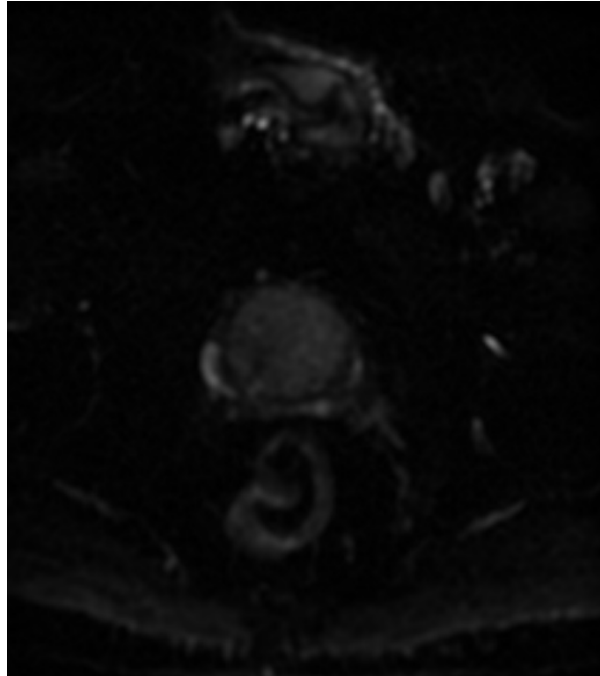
Axial DWI image for b=100 of the prostate of patient 01.0058 of the PCMM dataset
